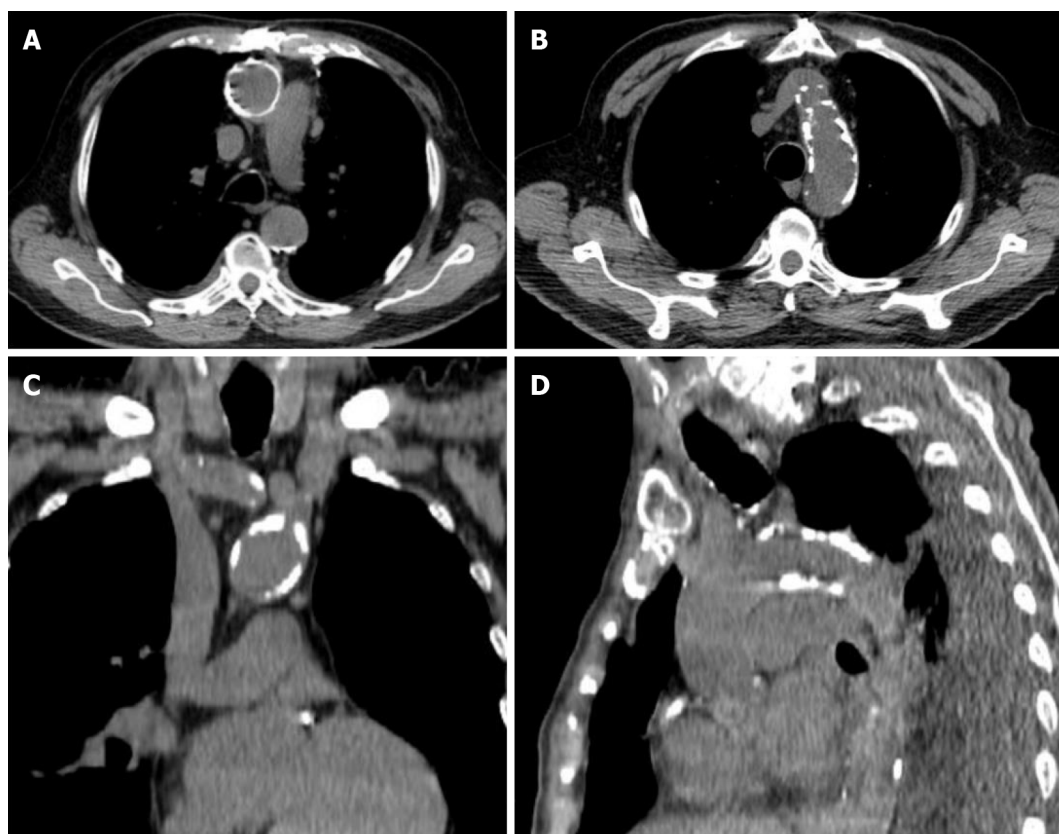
Porcelain aorta. Computed tomography reconstructions demonstrate circumferential calcification of the ascending aorta (A) and severe calcification of aortic arch (B-D).
